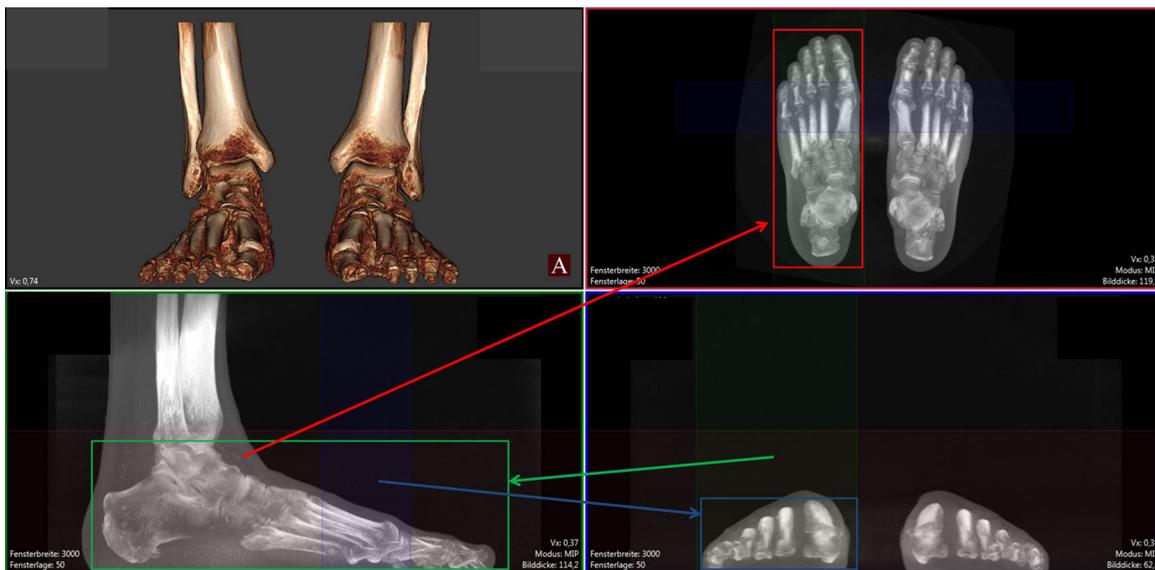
[17]. PedCAT software screen view with increased slice thickness to create virtual radiographs. Top right, in red frame, virtual dorsoplantar radiograph created by increased slice thickness that contains entire foot (red arrow). Bottom left, in green frame, virtual lateral radiograph created by increased slice thickness that contains entire foot (green arrow). Bottom right, in blue frame, virtual metatarsal head skyline view radiograph created by increased slice thickness that contains the metatarsal heads (blue arrow).
